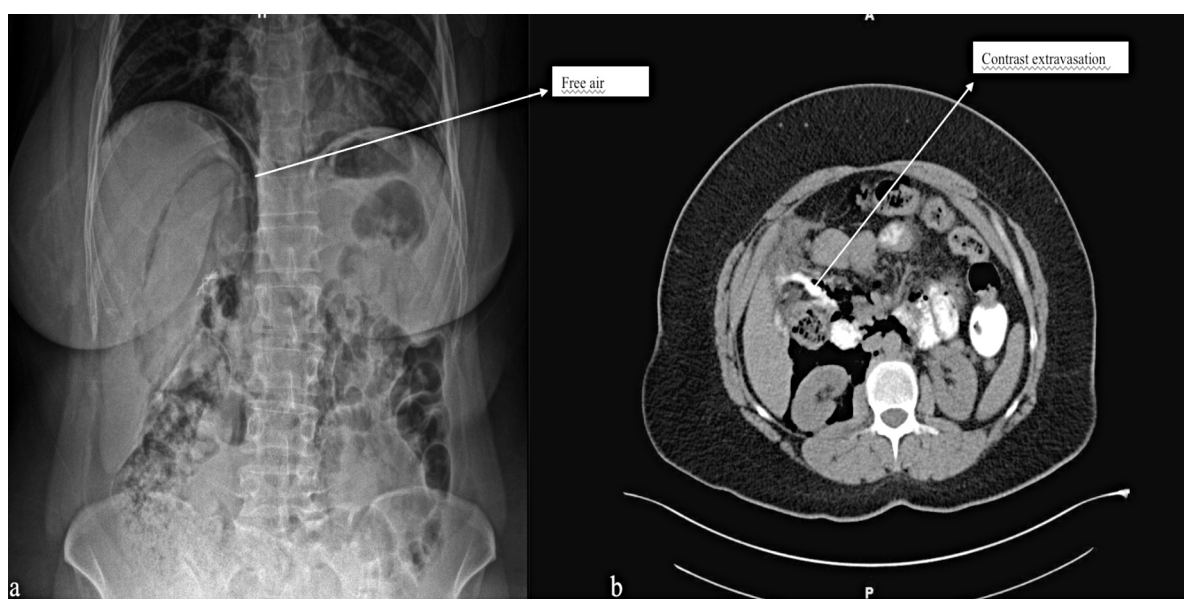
A) Free air in a standing flat abdominal x-ray taken in the patient with peritonitis findings after ERCP; B) In the same patient's oral contrast-enhanced abdominopelvic CT, both around the duodenum free-air images and extravasation of oral contrast agent.
